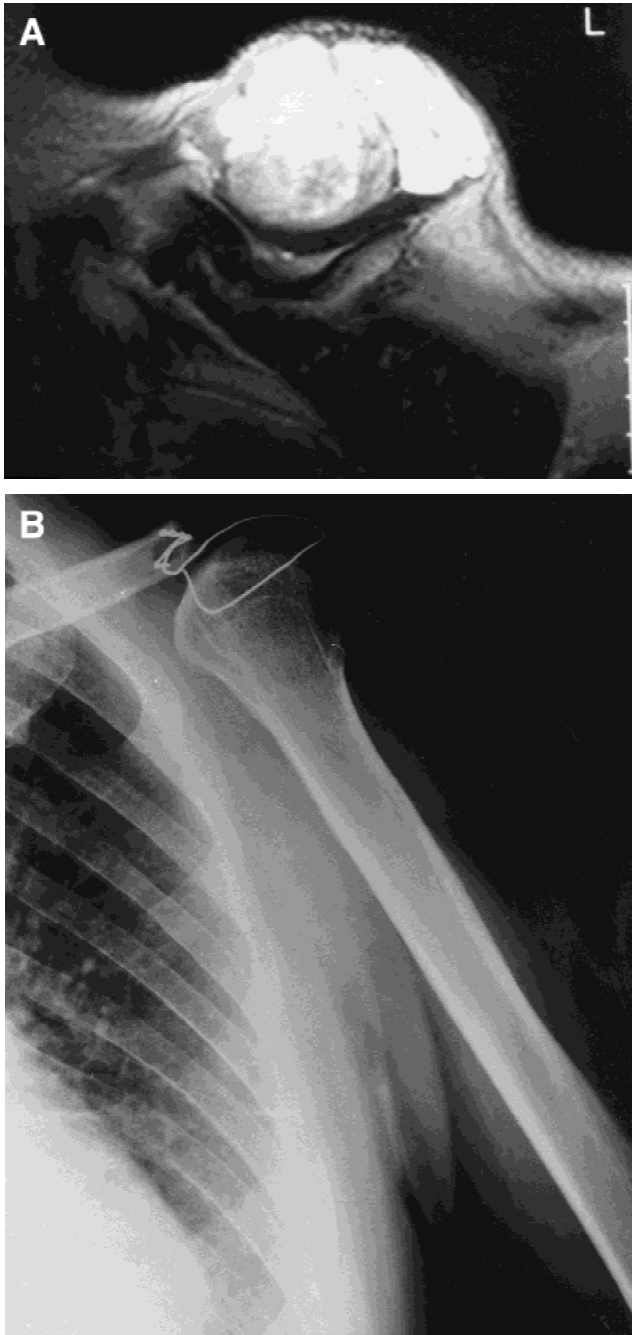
Case 5. A: Magnetic resonance image of leiomyosarcoma invading the scapula. B: Postoperative radiograph. In this case, a wire was used for augmentation of soft-tissue reattachment to the clavicle.
